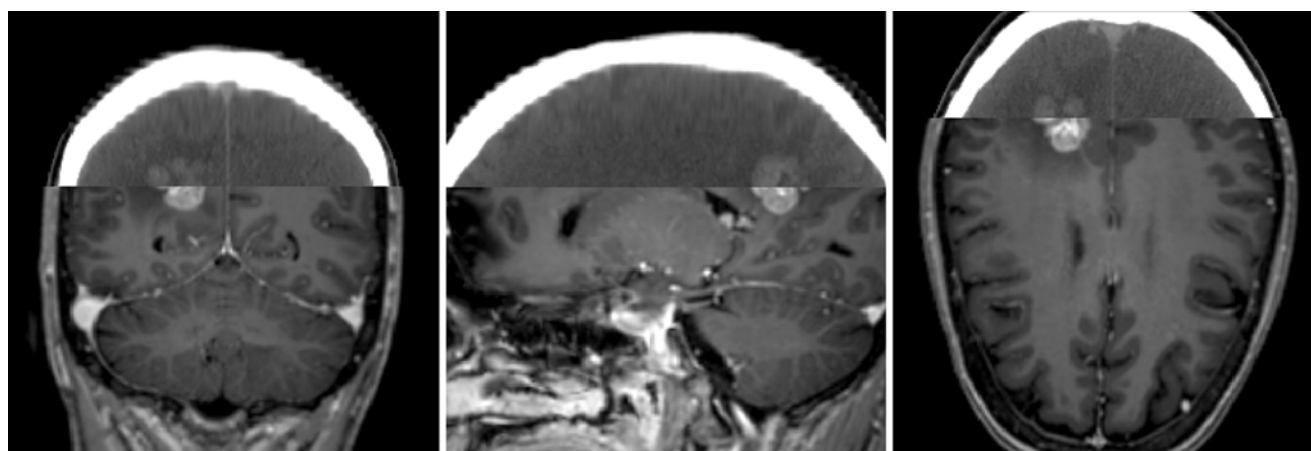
Split window display of image registration of MR and CT for a right parietal brain metastasis for SRS treatment planning in the axial (*right image*), sagittal (*middle image*), and coronal (*left image*) views
